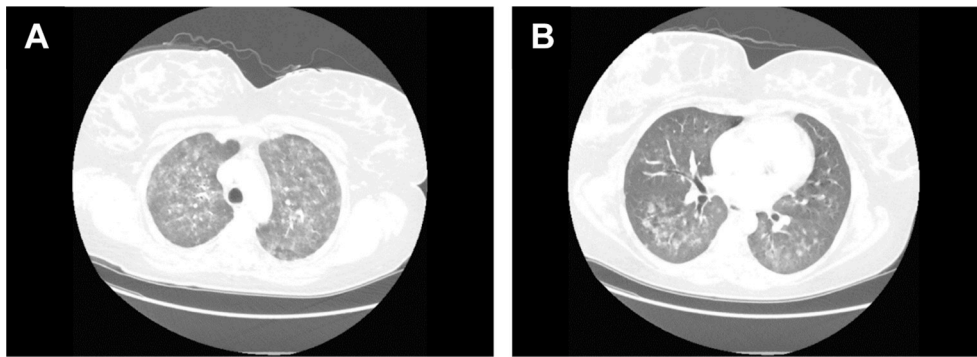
Chest CT scan on admission showed nodular ground glass opacities in the upper (A) and middle (B) lung zones.
